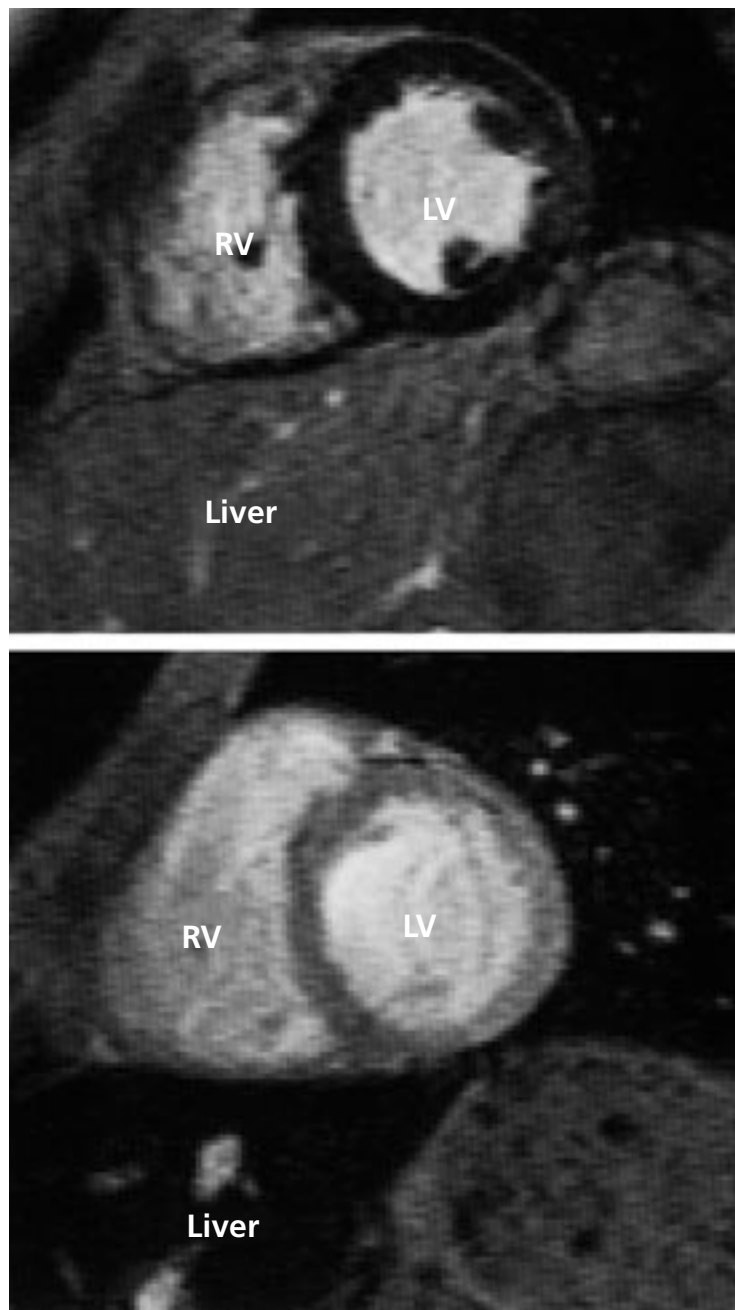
T2-star magnetic resonance images show discordance of iron deposition in the liver and in the heart. The top panel shows a patient with severe cardiac iron deposition but minimal liver iron deposition (heart darker than liver). The lower panel shows a patient with normal myocardial iron but severe liver iron overload (liver darker than heart). RV = right ventricle, LV = left ventricle
